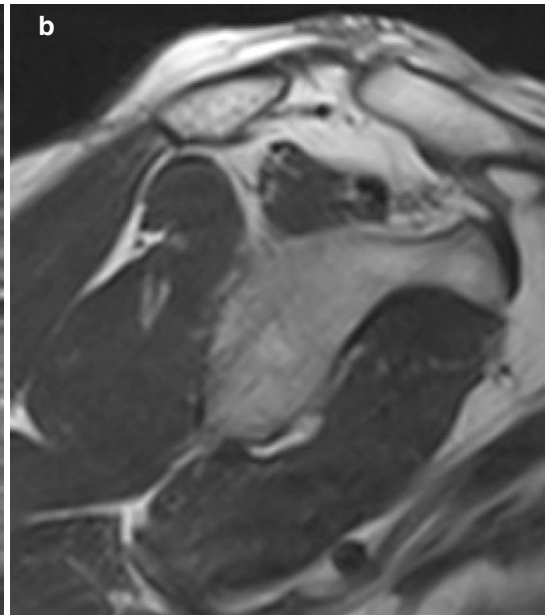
Right shoulder. Postoperative MRI after second surgery. (a) Coronal view: the supraspinatus tendon is re-torn
